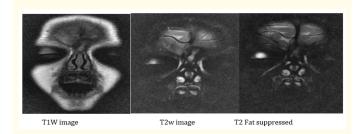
Magnetic Resonance Imaging (MRI) of the face revealed curvilinear sinus tract appearing hyper intense on T1w images and T2w images and hypointense on T2 fat suppressed coronal images extending from skin over glabella through nasal process of frontal bone running inferiorly in midline and opening to skin over the nose in the midline. No ramification or underlying bony erosion or intracranial extension was seen. These findings were suggestive of nasal dermoid cyst with sinus.
